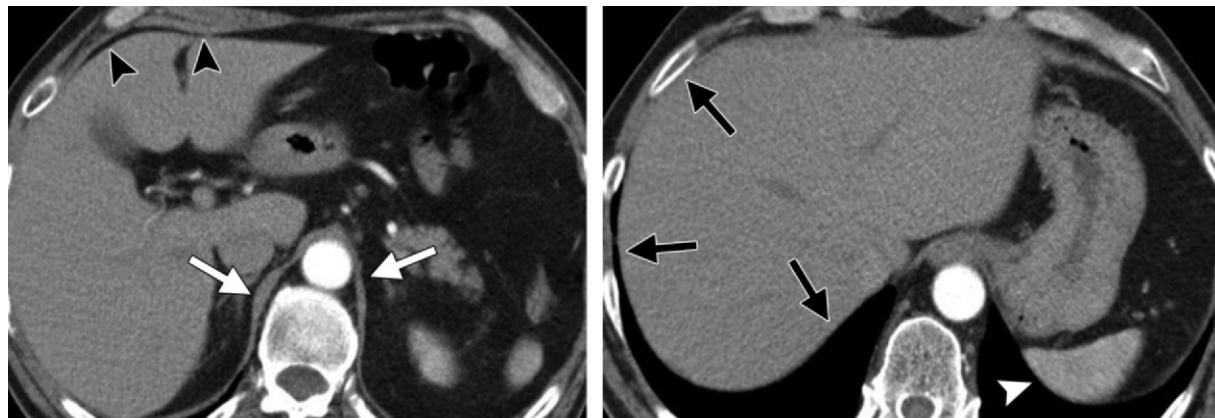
Normal anatomy. (a) Axial CT image provides good delineation of the diaphragm against the fatty layer along the liver (arrowheads) and crura (arrows). (b) Axial CT image obtained at a higher level in the same patient shows poor delineation of the diaphragm in the absence of an interposed fat layer between it and both the liver (arrows) and spleen (arrowhead). In the normal anatomy, both hemidiaphragms are dome shaped, and the abdominal structures are separated from the posterior chest wall by the costophrenic sulcus, which contains both lower lung lobes.
